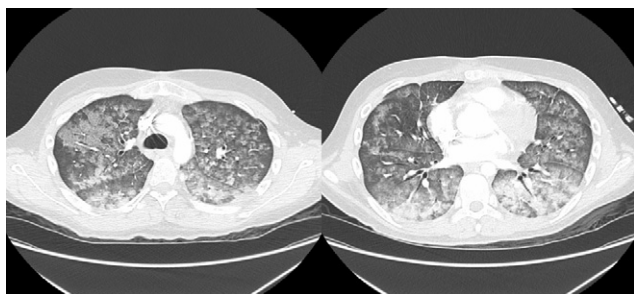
CT chest (2 slices) showing diffuse pulmonary haemorrhage. Both Figs. 1 and 2 reproduced with permission.
